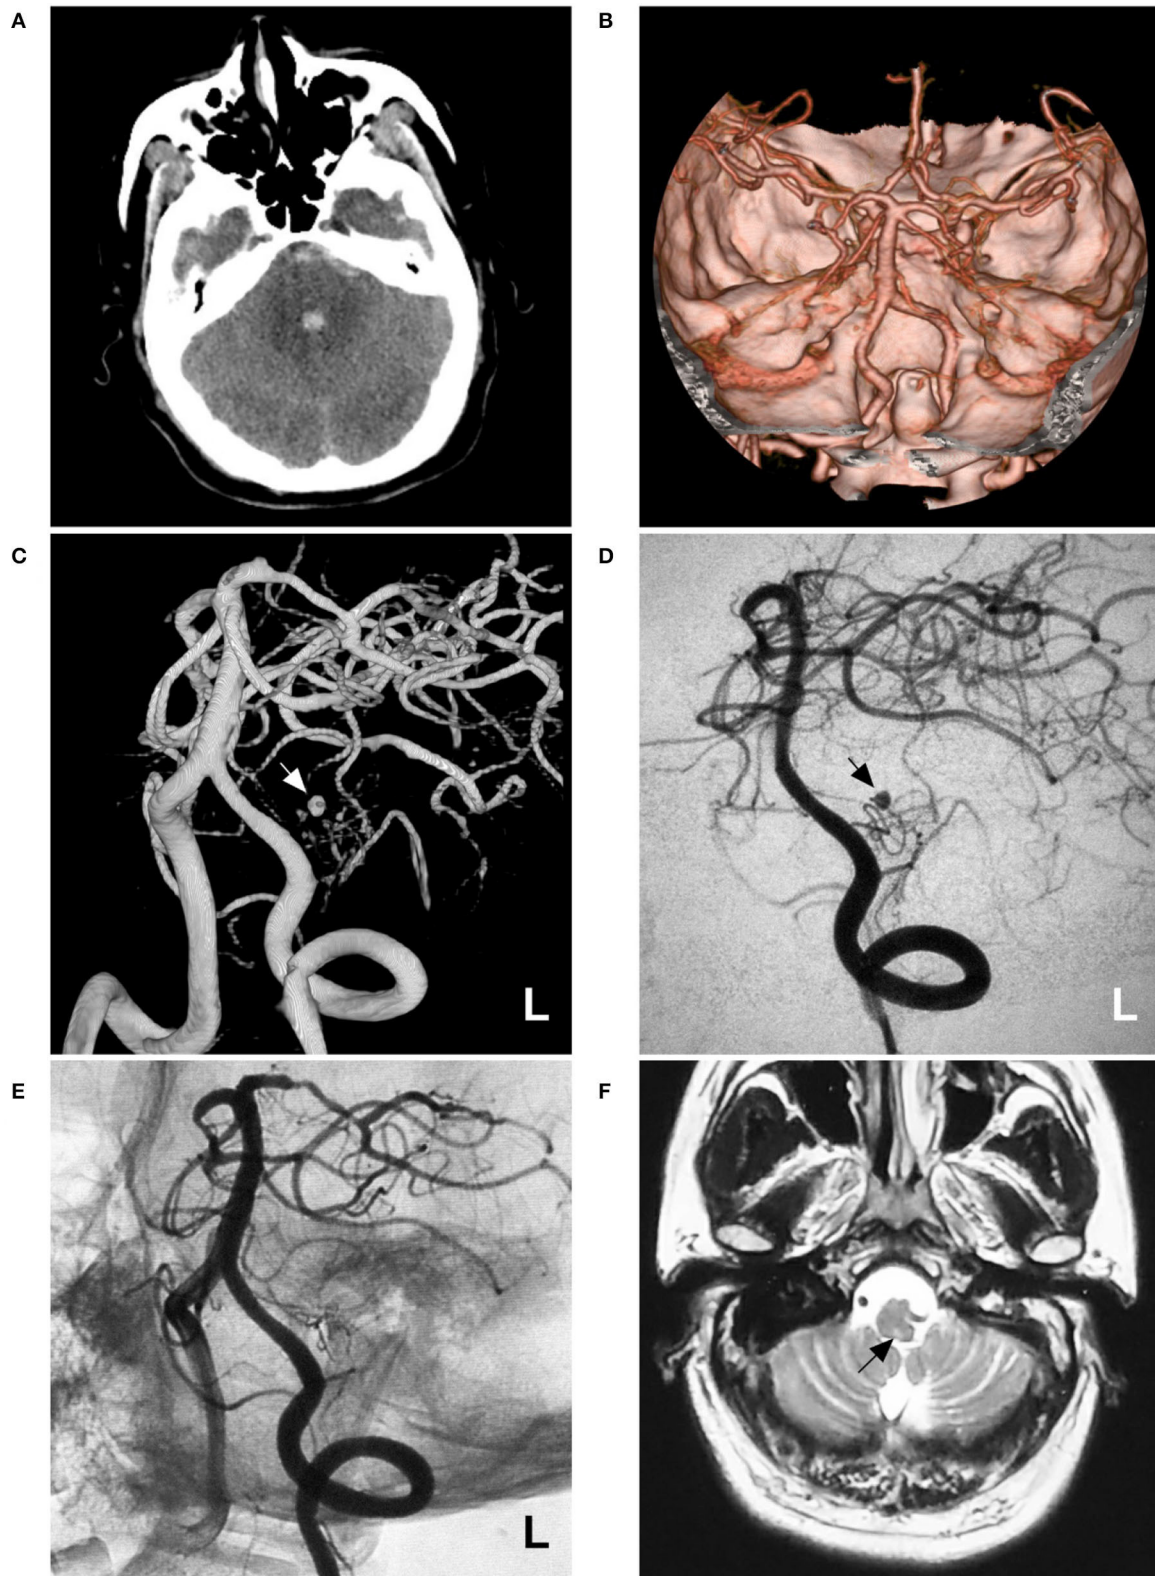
Imaging of case 1. (A) CT shows subarachnoid hemorrhage concentrated at the perimesencephalic cistern with involvement of the fourth ventricle. (B) CTA reveals no underlying vascular lesions. (C,D) Angiograms of the left VA show a pseudoaneurysm (arrow) located in the hypoplastic and plexiform PICA. (C) shows a three-dimensional angiogram, and (D) shows a two-dimensional angiogram. (E) Angiogram of the left VA shows that the aneurysm and parent PICA are cast with Onyx, and other branches are visualized. (F) Follow-up MRI scan shows a minor brainstem infarction (arrow). CT, computed tomography; CTA, CT angiography; L, left; MRI, magnetic resonance imaging; PICA, posterior inferior cerebellar artery; VA, vertebral artery.
